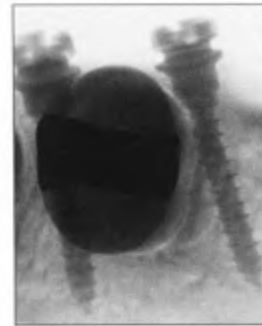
Experimental three-dimensional radiograph of mini-screw insertion point.
